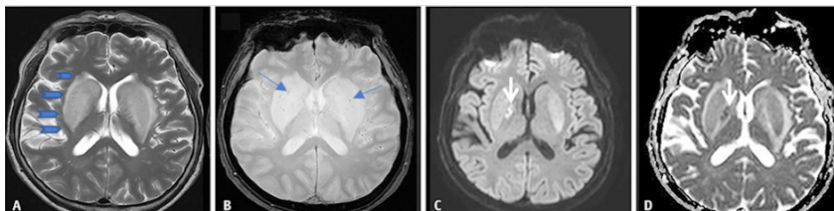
In the context of uremic encephalopathy in diabetic patients, T2-weighted images in A and B show bilateral hyperintense vasogenic edema (arrowheads) in the basal ganglia and areas of focal hemorrhage (thin arrows). In C and D, diffusion and apparent diffusion coefficient (ADC) images demonstrate areas of cytotoxic edema (arrows) in the basal ganglia associated with vasogenic edema. (13)
